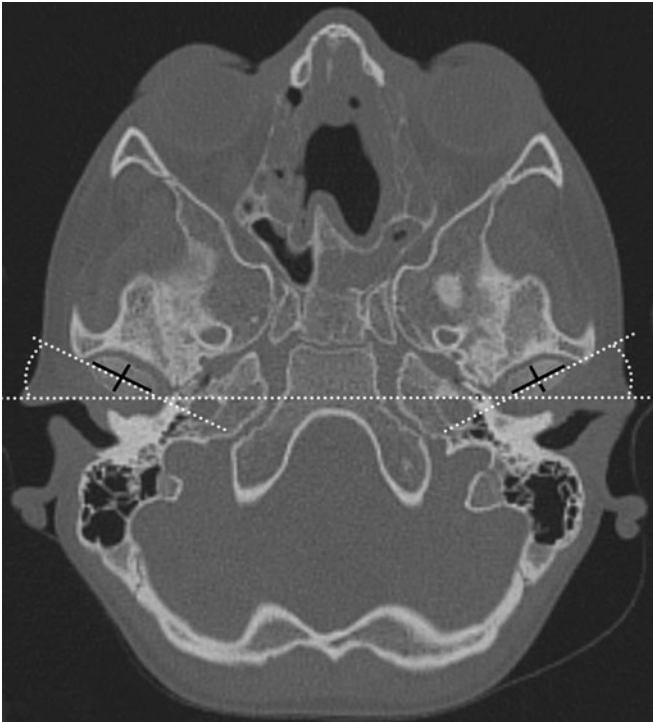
Transverse computed tomography imaging plane showing the left-to-right (LRD, *longer black line*) and anterior-to-posterior (APD, *shorter black line*) diameters as well as the anteverision angle (AA) measurements (*white dotted lines*) of the mandibular condyles
